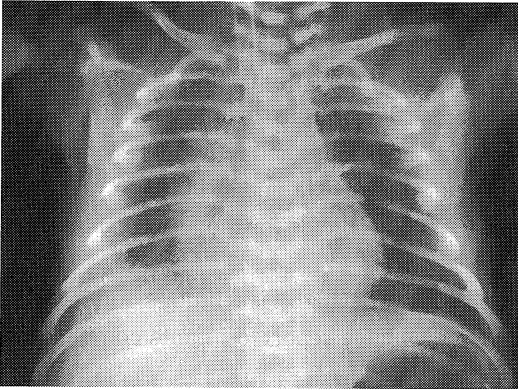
Chest X-ray 6 hours after birth.
